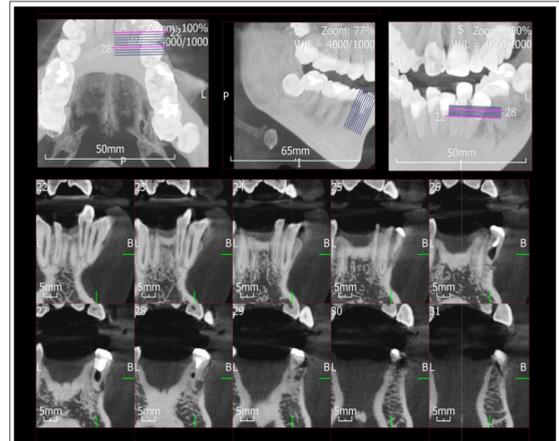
Coronal CBCT of mandibular left region after 6 years postoperative
